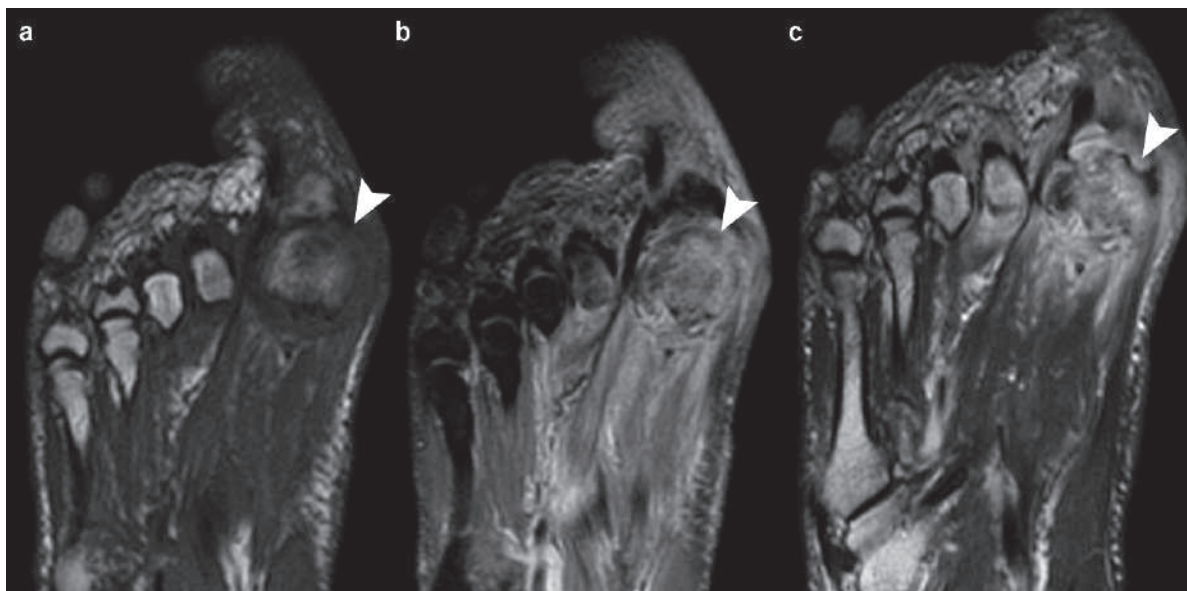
Coronal T1W (a), STIR (b), and T1W postcontrast foot MRI of a patient investigated for gout with foot pain localized to the big toe show hypointense signal intensity due to edema of the first metatarsal head in (a), hyperintense T2 signal
